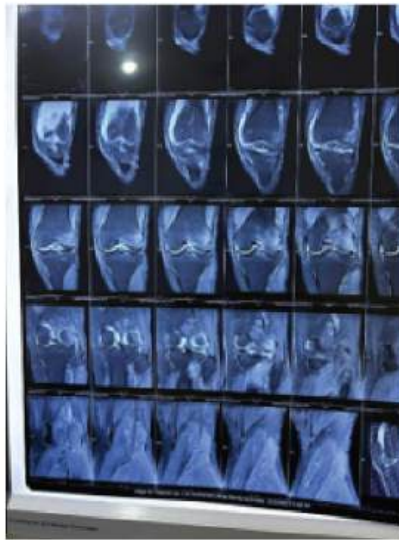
Coronal section of Right knee joint MRI
